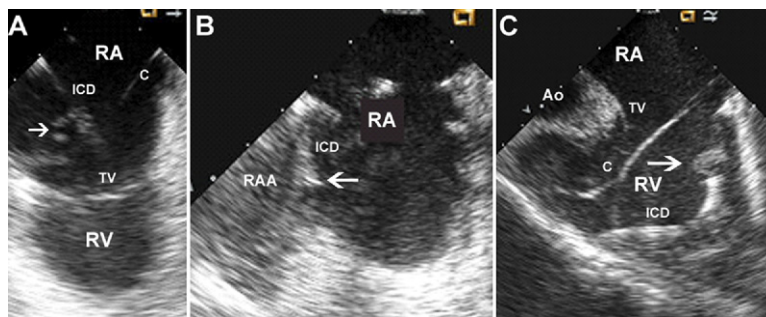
Intracardiac Echocardiographic Imaging of a Mobile Thrombus Attached to Intracardiac Leads
